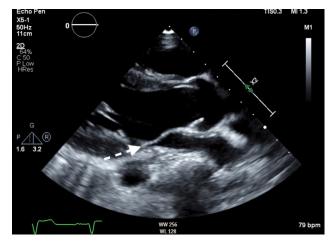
Parasternal long-axis 2D view from TTE showing mitral valve systolic phase. The *arrow* points to the closed anterior mitral leaflet that is redundant and covers the mitral annulus plane with no posterior leaflet seen at the coaptation line.
